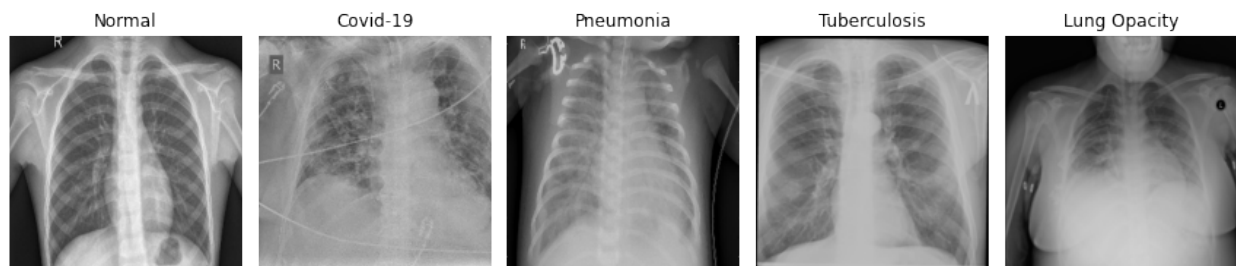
Chest X-ray Images Multi Classification
